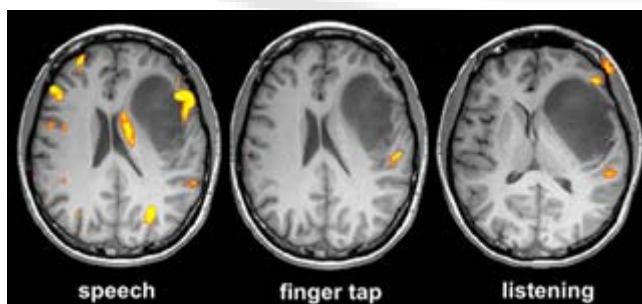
In functional MRI, brain areas “light-up” when performing certain tasks
